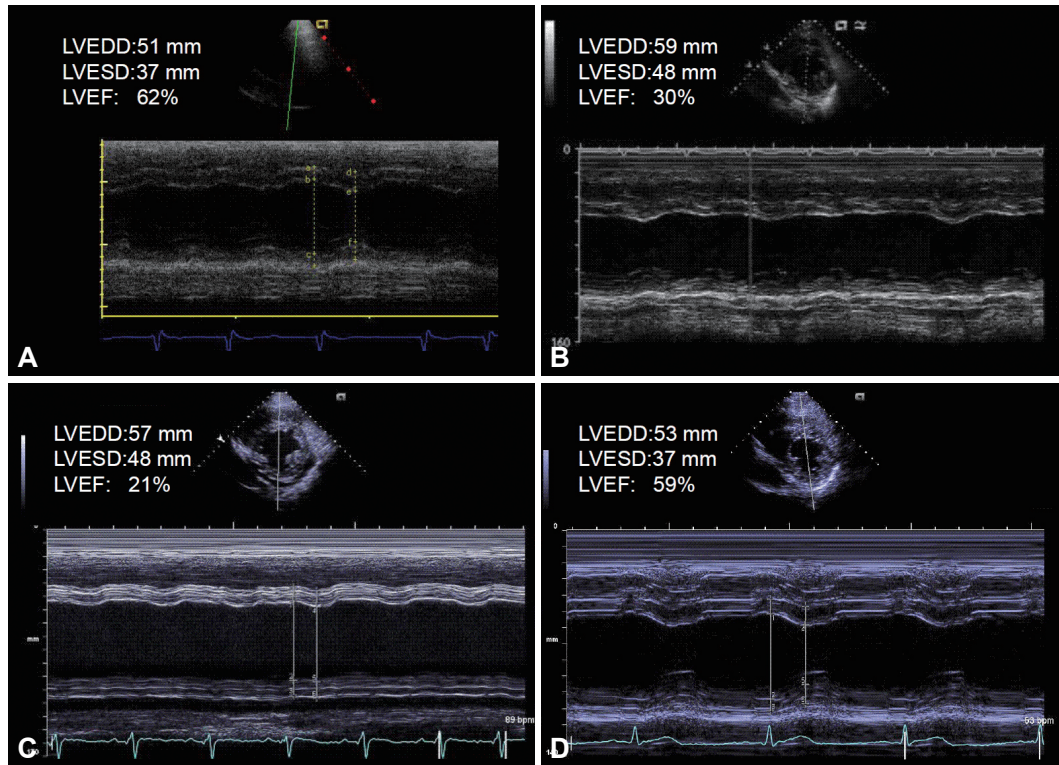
Serial M-mode echocardiograms of the left ventricle of the patient, taken at the first postoperative day (A) shows atrial fibrillation (heart rate 94 beat per minute), 9 weeks after orthotopic liver transplantation (B) shows atrial fibrillation (heart rate 109 beat per minute), 6 months after liver transplantation (C) with sinus rhythm (heart rate 89 beat per minute), and 8 months (D) after implantation of an implantable cardioverter-defibrillator with sinus rhythm (heart rate 63 beat per minute). LVEDD: left ventricular end-diastolic dimension, LVESD: left ventricular end-systolic dimension, LVEF: left ventricular ejection fraction.
